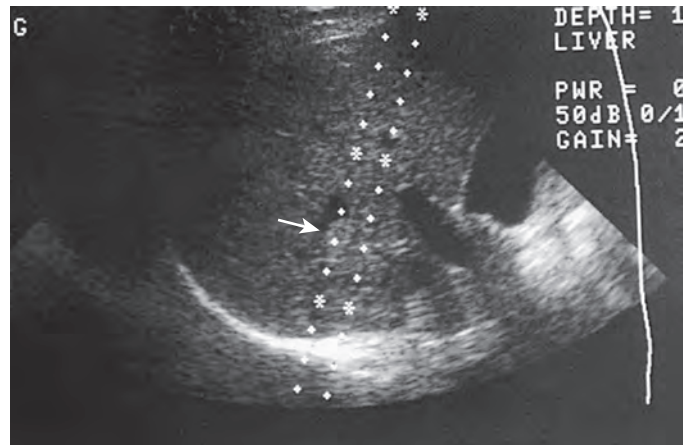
Ultrasonogram of a 63-year-old man with small cell lung cancer. Gray-scale ultrasound reveals a large hypoechoic mass located deep in the left hepatic lobe (arrow). The mass underwent biopsy percutaneously by a subcostal approach. Fine-needle aspiration revealed metastasis.
